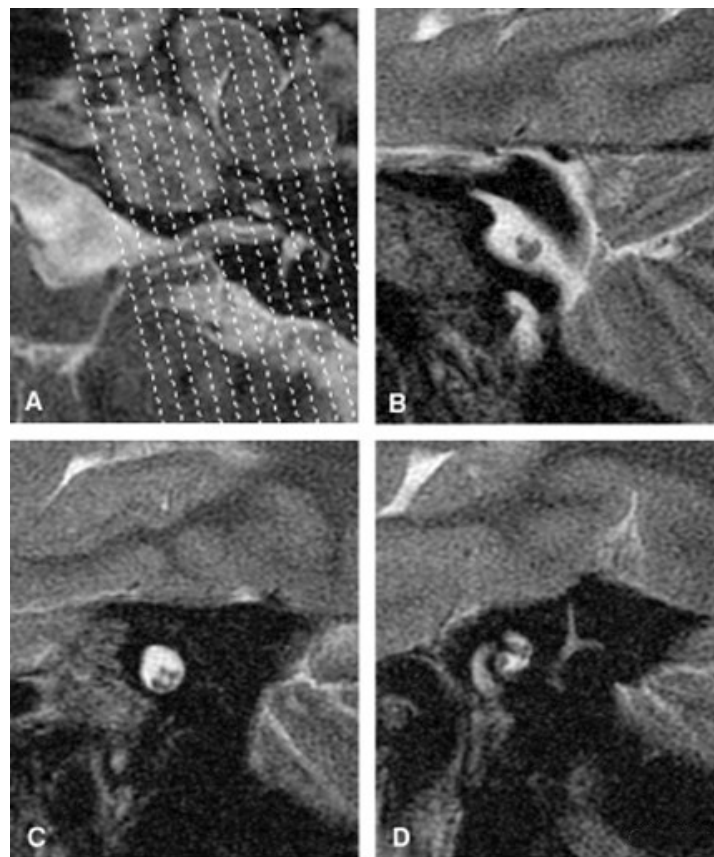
High-resolution T2-weighted images of the left internal auditory canal showing the localization of facial and vestibulocochlear nerves within the IAC
